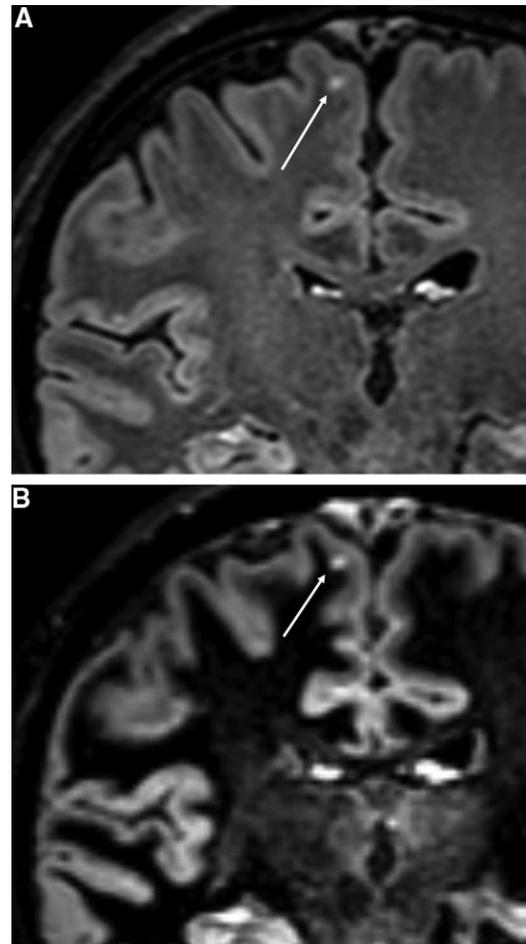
A 38-year-old man with MS examined using coronal 3D FLAIR and 3D DIR imaging. (A) Coronal 3D FLAIR and (B) 3D DIR images of the right frontal lobe show a juxtacortical MS lesion (arrows A and B). Lesion topography is better depicted on the 3D DIR image (arrow B) than on the 3D FLAIR image (arrow A).
